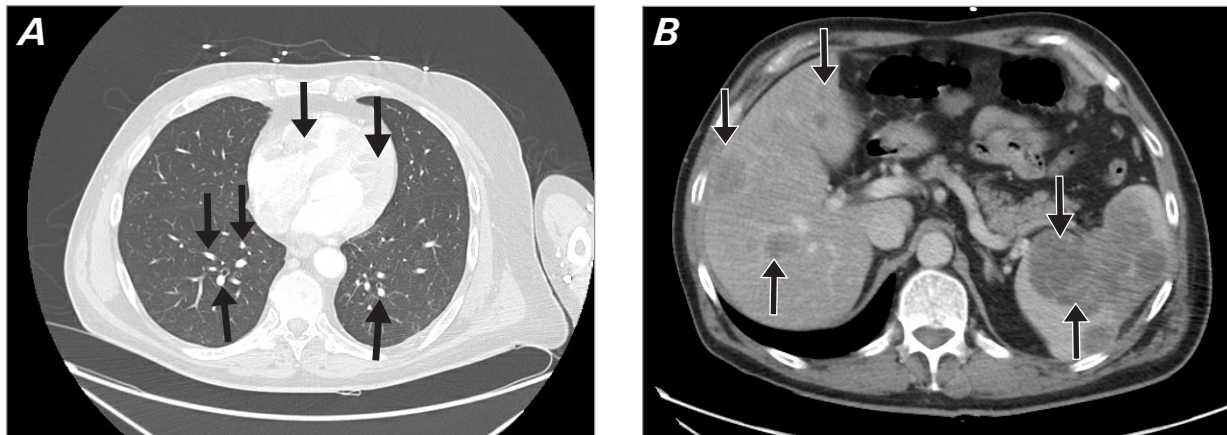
A) Chest computed tomographic scan shows multiple pulmonary nodules without pleural effusion or pneumothorax nodules (3 arrows in the right lung and 1 arrow in the left lung indicate metastatic lung nodules). In addition, normal heart size is seen with a hypoattenuating mass in the left ventricle without pericardial effusion and a small mass in the right ventricle (arrows in the heart indicate metastatic hypoattenuating masses in both ventricles). B) Abdomen computed tomographic scan shows multiple small masses in the liver and the spleen (3 arrows in the liver and 2 arrows in the spleen indicate metastatic nodules).
